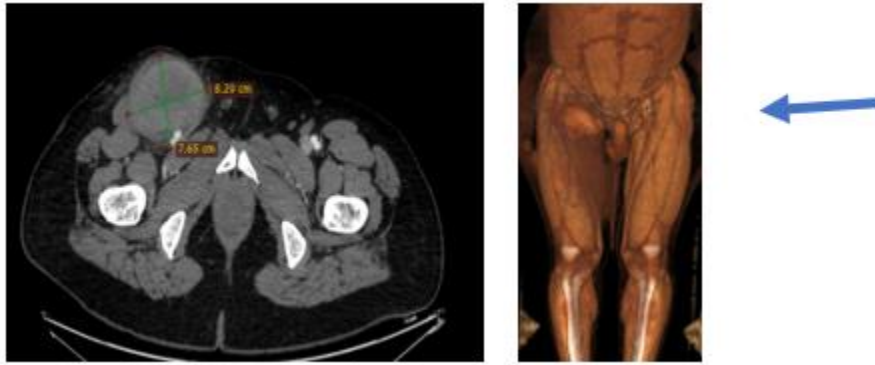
CT angiography: large pseudoaneurysm in right femoral artery
